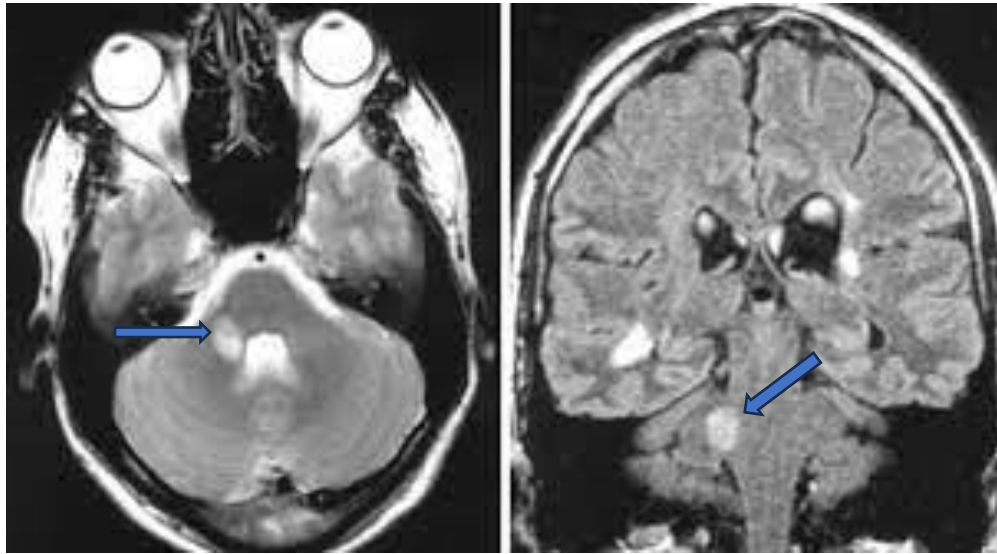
Brain MRI images showing an MS plaque in the pons near the CN 5 root entry zone (REZ) (blue arrows)
